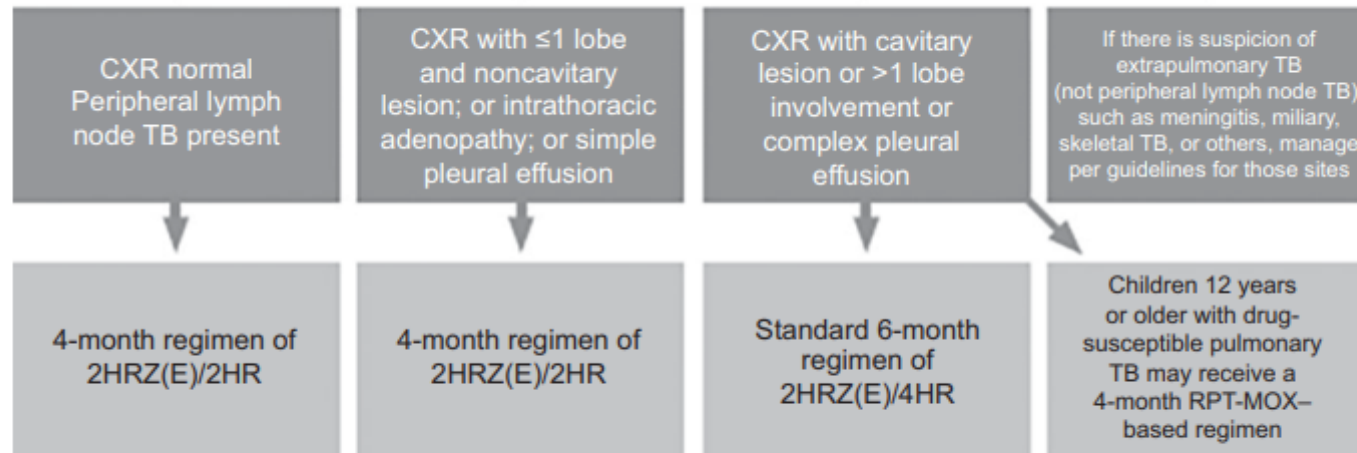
Identifying children eligible for 4-month regimens. Figure developed by the Joint Panel on the basis of data in the SHINE trial and Study 31/A5349 to address eligibility of some children for either the RPT/MOX regimen or the 4-month standard drug regimen. CXR = chest x-ray; HRZE = isoniazid, rifampin, pyrazinamide, ethambutol; RPT-MOX = rifapentine-moxifloxacin.
